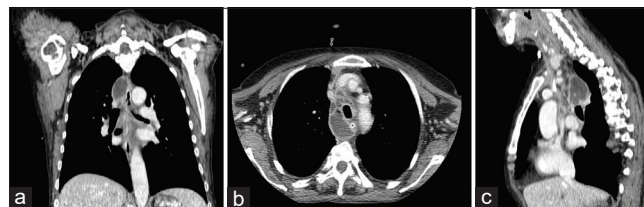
Chest computed tomography on the 4th day; abscesses were located in the upper mediastinal space and in the right paraesophageal and paratracheal spaces. (a) Coronal projection; (b) Axial projection; (c) Sagittal projection
